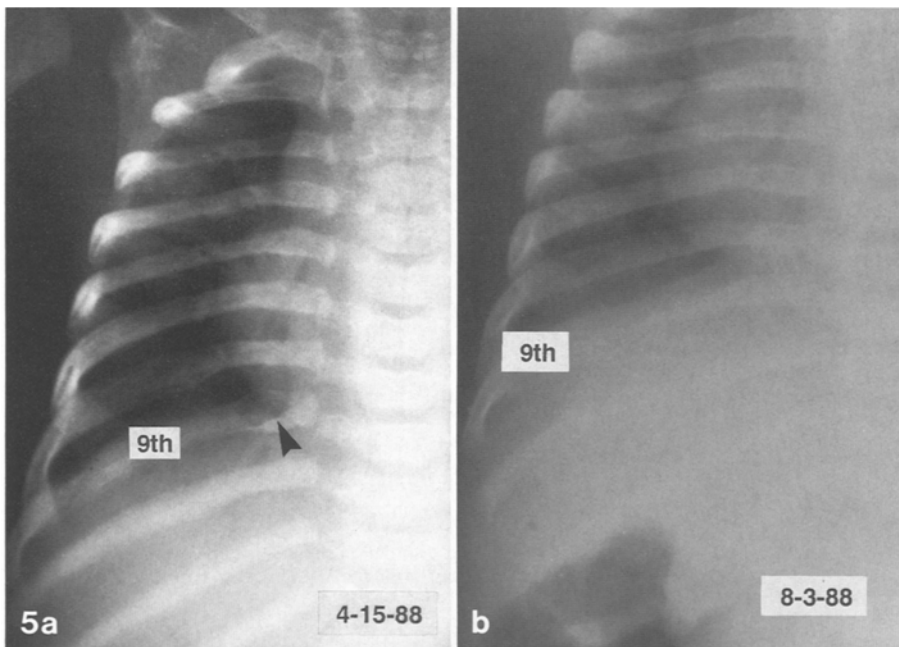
a, b. a Case 2 – AP View Of Right Rib Cage (4-15-88) – There is a lytic, expansile lesion in the ninth rib posteriorly. The ninth rib more laterally is also slightly irregular. This rib was normal in a chest X-Ray four months earlier. The lesion is consistent with a “subperiosteal resorption cyst.”
